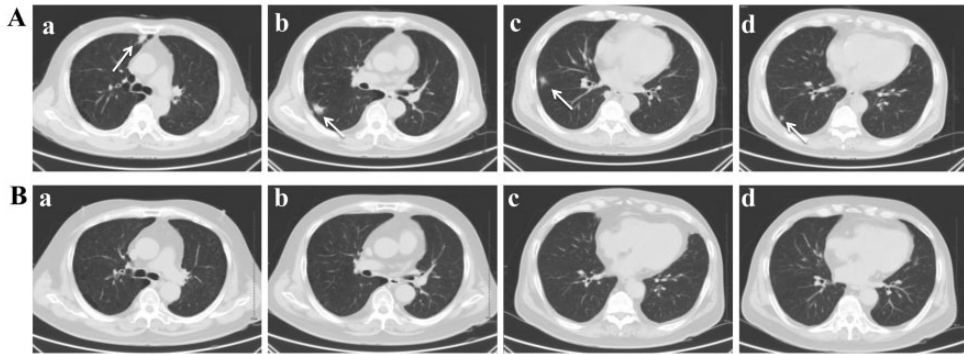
Lung masses and lesions after computed tomography (CT)-guided cryoablation and chemotherapy. (a) CT after cryoablation of the mass in the left upper lung lobe (a, April 2013), the nodule in the right upper lung lobe (b, April 2013), and the nodule in the left upper lung lobe (c, May 2014). (b) The lung lesions were evaluated after cryoablation and chemotherapy, showing that the right upper lobe lesion had decreased in size, whereas the left upper lobe nodule had not (a and b, May 2014). Follow-up in October 2015 showed that both lesions, in the left and right upper lobes, had decreased in size (c and d).
